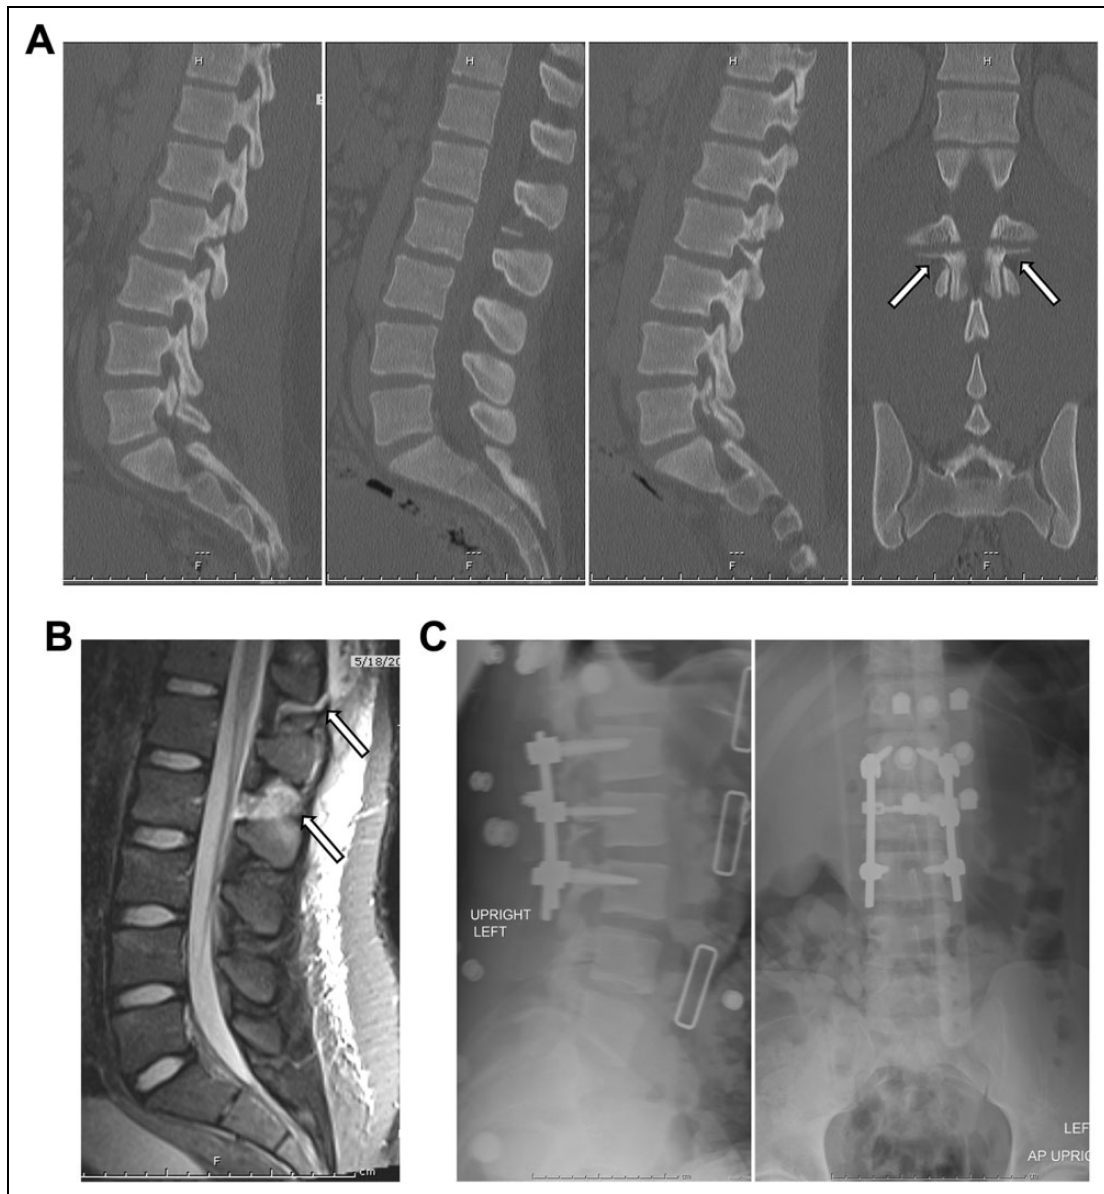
Patient 1 was an 18-year-old male who came in after a road traffic accident. He presented with severe back pain but was neurologically intact, and he had an associated left femur fracture. (A) CT image with acute bilateral pars fracture at L2 (Dimer classification Type 3). Grade I anterior listhesis on radiographs (not shown) reduces on supine position. Note the chronic spondylolysis at L5. (B) No disc injuries noted on T2-weighted MRI scan, but had acute injuries to the interspinous ligament at L1-L2 and L2-L3. (C) Posterior spinal instrumentation with posterolateral fusion was done from L1-L3 after reduction. Maintenance of instrumentation and fusion was documented, with no reported pain or deficits on last follow-up 4 years post injury.
